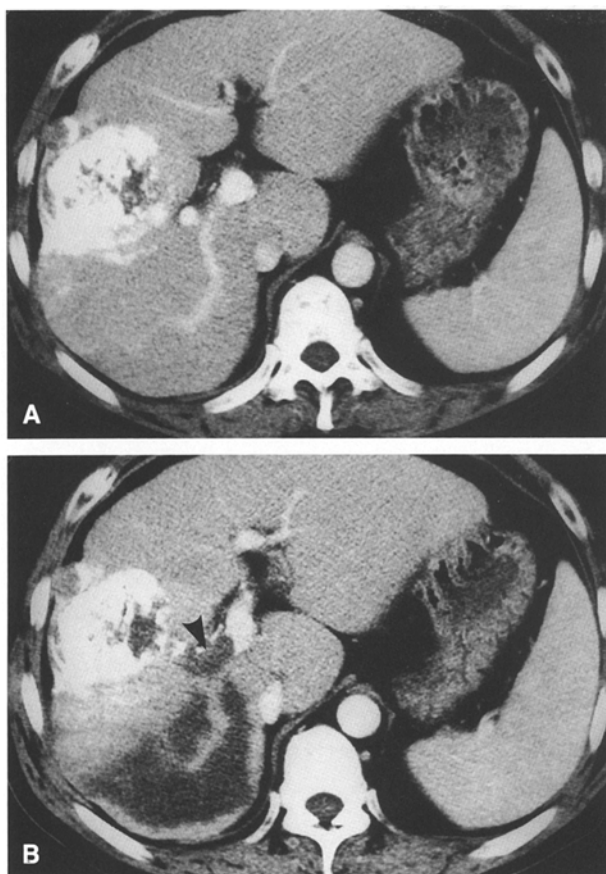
A 42-year-old man with nodular hepatoma treated by iodized oil/cisplatin with Gelfoam particles. A Contrast-enhanced CT obtained 1 week after TAE shows accumulation of iodized oil in the tumor. The patient experienced sudden abdominal pain and fever 2 weeks after TAE, and abdominal CT was obtained. B Contrast-enhanced CT shows a hypodensity area in the posterior segment of the right lobe, which proved to be an infarction on operation. Note the tumor thrombi which developed in a branch of the portal vein after TAE (*arrowhead*). Peripheral branch of the portal vein is seen in the infarcted area.
